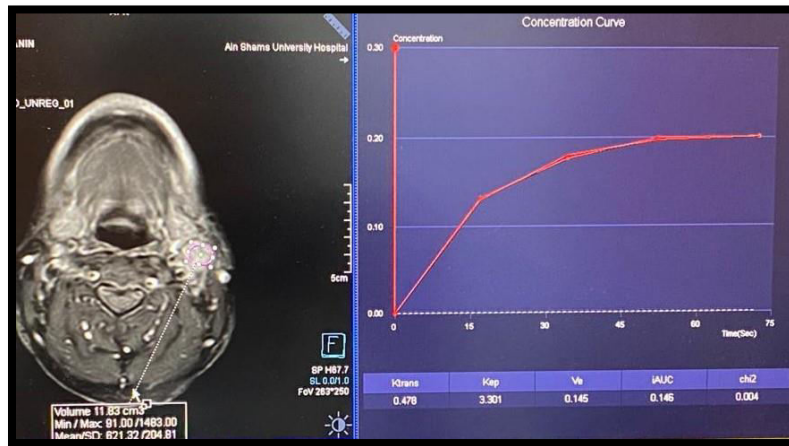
Shows ROI over a nodal site of metastatic SCC before (upper image) and after (lower image) treatment with the DCE-MRI parameters obtained in both settings.
